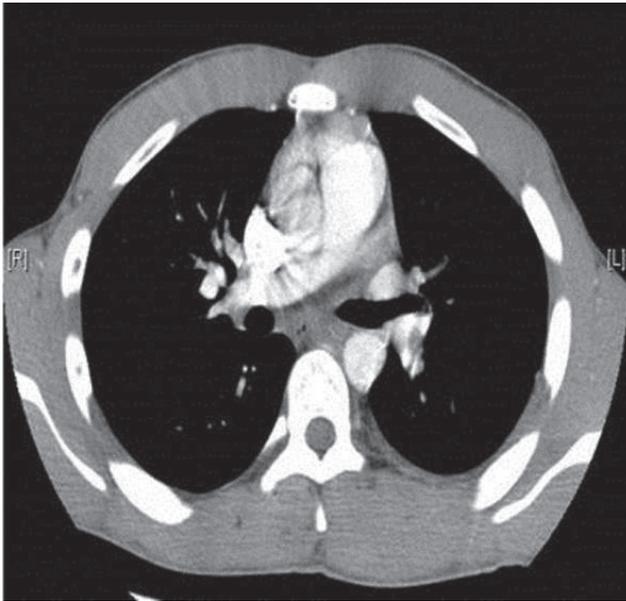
Spiral CT showed bilateral PEs.
